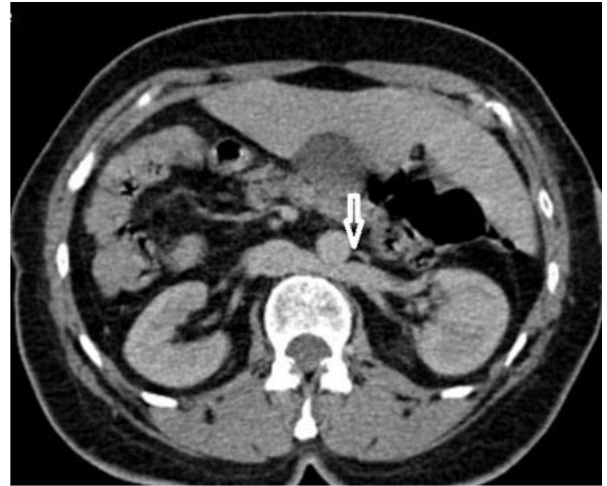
Enhanced abdomino-pelvic CT scan at the portal phase showing a retroaortic left renal vein (arrow).
